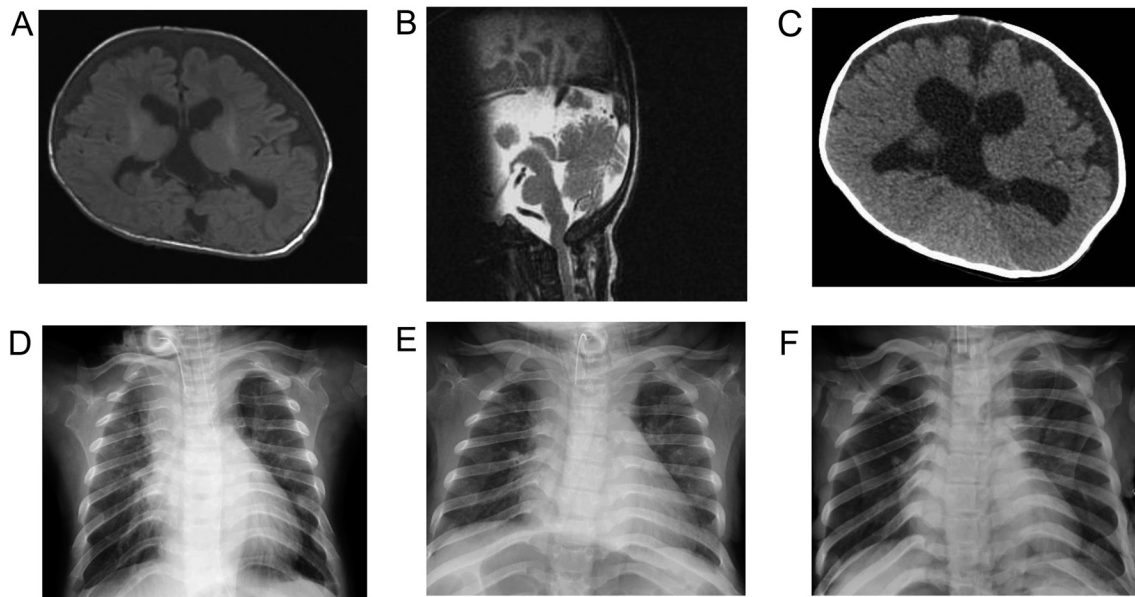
(A) (B) Cranial and spinal MRI findings at 1 month. Upper cervical spinal cord compression with ventricular enlargement and narrowing of the foramen magnum are seen. (C) At 4 mo, a cranial CT scan shows progressive hydrocephalus. Chest radiographs after initiation of GH treatment, (D) at 6 yr 1 mo, (E) at 12 yr 1 mp, and (F) at 17 yr 8 mo, respectively.
